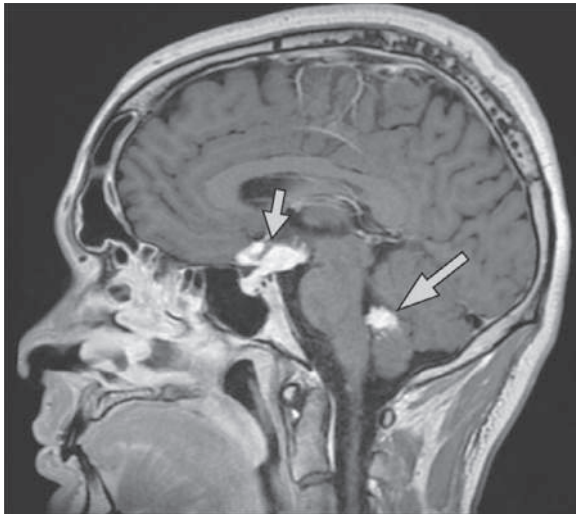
Neurologic involvement in sarcoidosis. Typical involvement of hypothalamus, pituitary gland, and optic chiasm seen on a sagittal gadolinium-enhanced T1-weighted sequence MRI (small arrow). Abnormal nodular enhancement of the fourth ventricle is seen (large arrow). (Modified from Valerye D, Prasse A, Nunes H, et al. *Sarcoidosis*. *Lancet*. 2014;383:1155–1167, Fig. 3D, p. 1160.)
